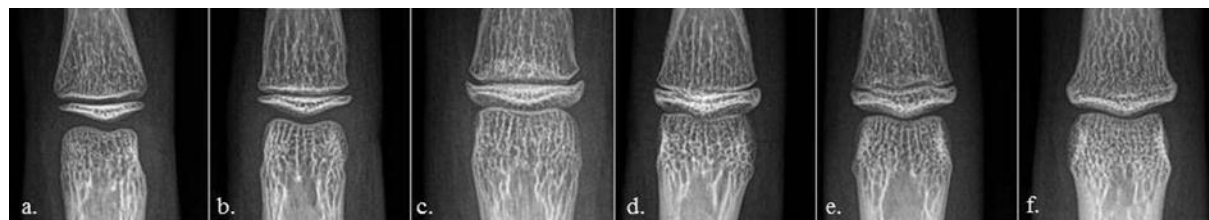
Positioning of the x-ray tube to obtain images of MP3 region.Figure 2: Six morphological stages of the MP3 during puberty according to Rajagopal and Kansal (8).
